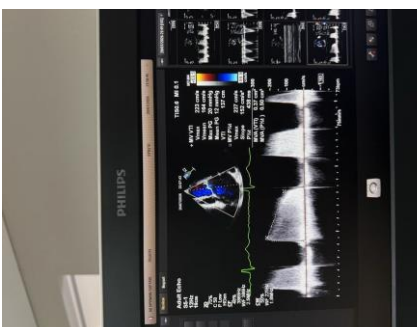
Continuous-wave Doppler assessment demonstrating an elevated mean transmitral gradient of 12 mmHg, with mitral valve area measurements of 0.37 cm² by the velocity-time integral method and 0.50 cm² by pressure half-time.
